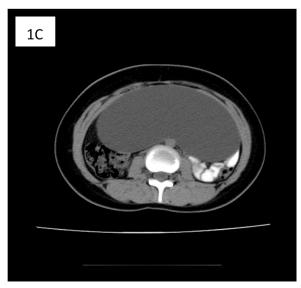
A-C. CT images showing a large cystic well defined lesion (19x23cm) occupying the lower abdomen compressing the adjacent structures.
